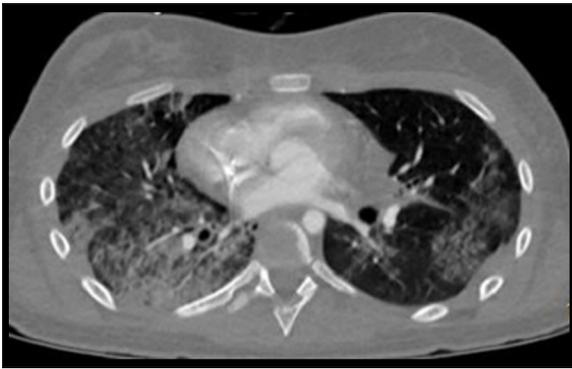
CT angiography: diffuse alveolar haemorrhage.
